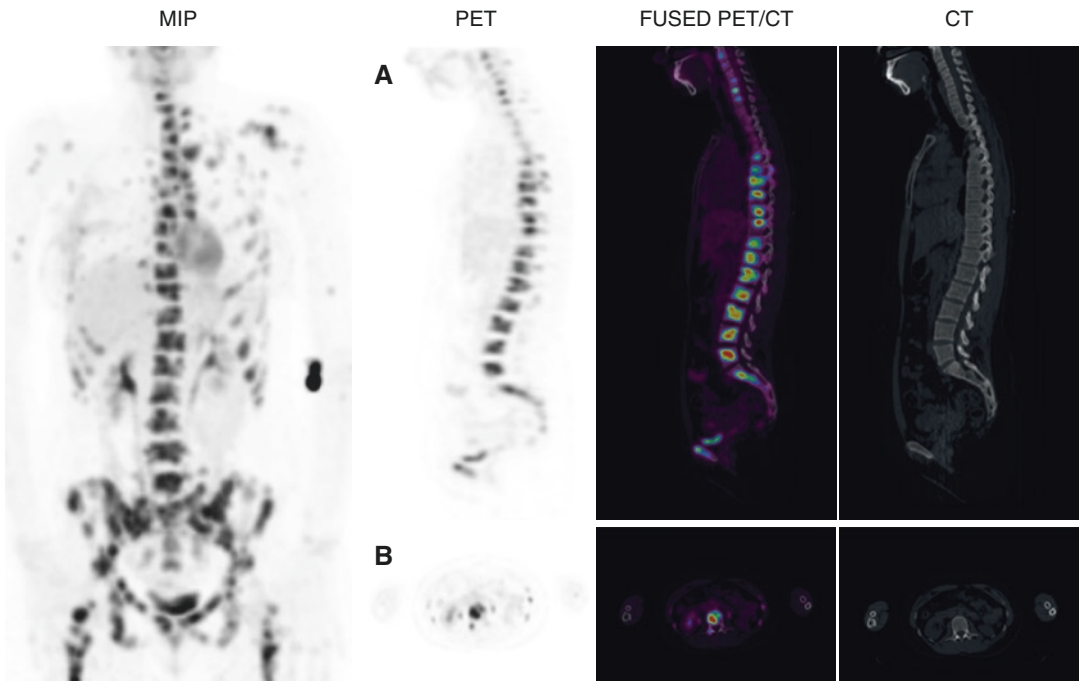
In the second study, 2 months later, several new bone and hepatic lesions were seen, and the known lesions show increased FDG uptake. Moreover, the lung chemotoxicity has progressed (row C)
